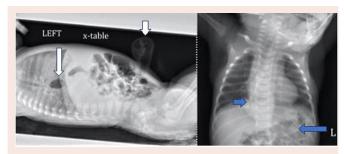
Cross table radiograph (left) showing large umbilical hernia (small white arrow) and hiatal hernial above the diaphragm (long white arrow). AP radiograph (right) shows two nasogastric tubes with one entering the herniated part of the stomach (small blue arrow) and the other in the correct placement (long blue arrow).
